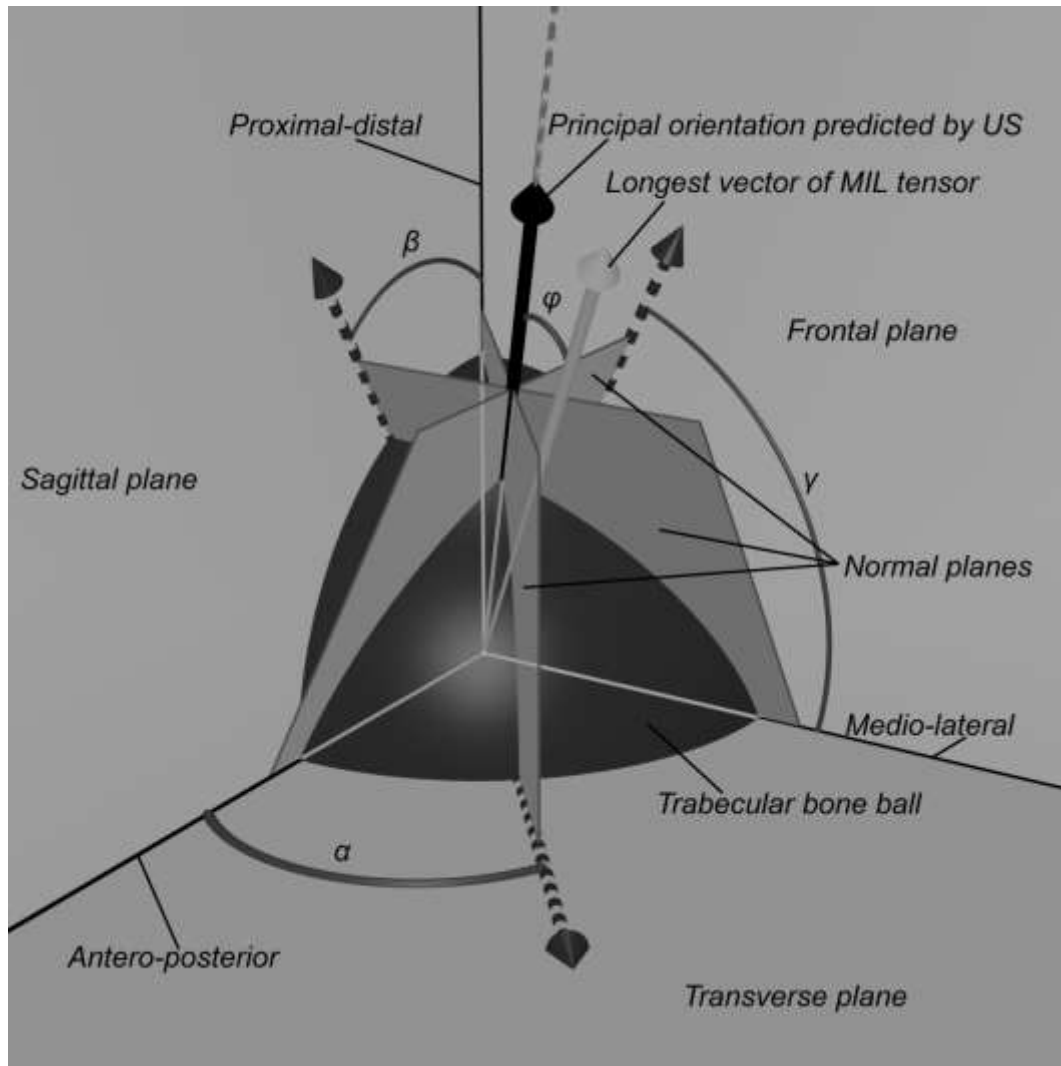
The trabecular bone ball (dark sphere) was placed in a Cartesian coordinates system defined by the orthogonal anatomical planes (frontal, sagittal and transverse planes) with the center of the ball placed at the origin of the coordinates. Based on the rotational ultrasound measurement around 3 anatomical axes, the angles α , β and γ were determined. These are the angles in which the ultrasound measurements obtained peak values. According to these angles, three vectors (dash arrows) on the corresponding orthogonal anatomical planes were determined, i.e., the vector on the transverse plane is determined by the ultrasound measurements around proximal-distal axis. Along the direction of each of these 3 vectors, a plane was defined normal to the corresponding anatomical plane. These normal planes (gray planes) intersect at one line (dash line). The normal vectors of these normal planes were used to define the intersection line using Equation (3.3) and Equation (3.4). A vector (dark arrow) along the direction of that intersection line is defined as the principal orientation predicted by ultrasound, and the angle
